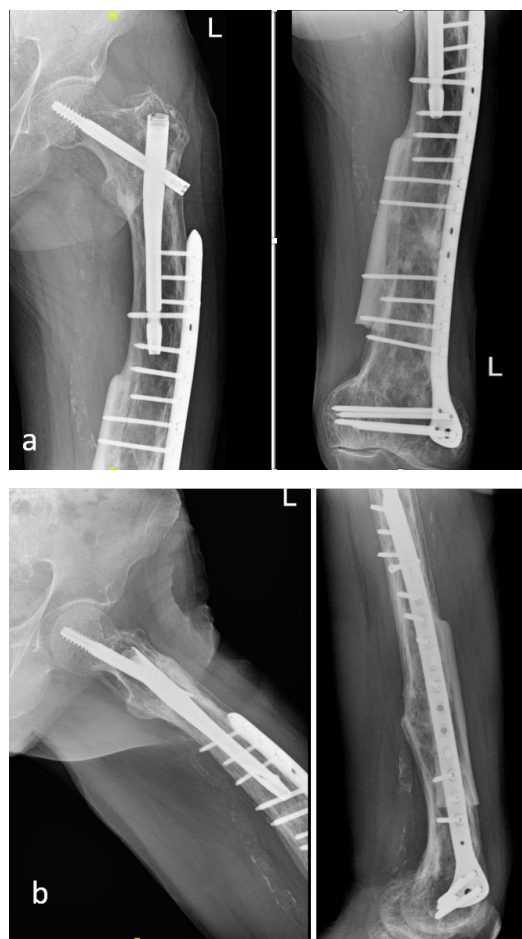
Radiographs (a,b) showing the union fractures at 1-year follow-up.
